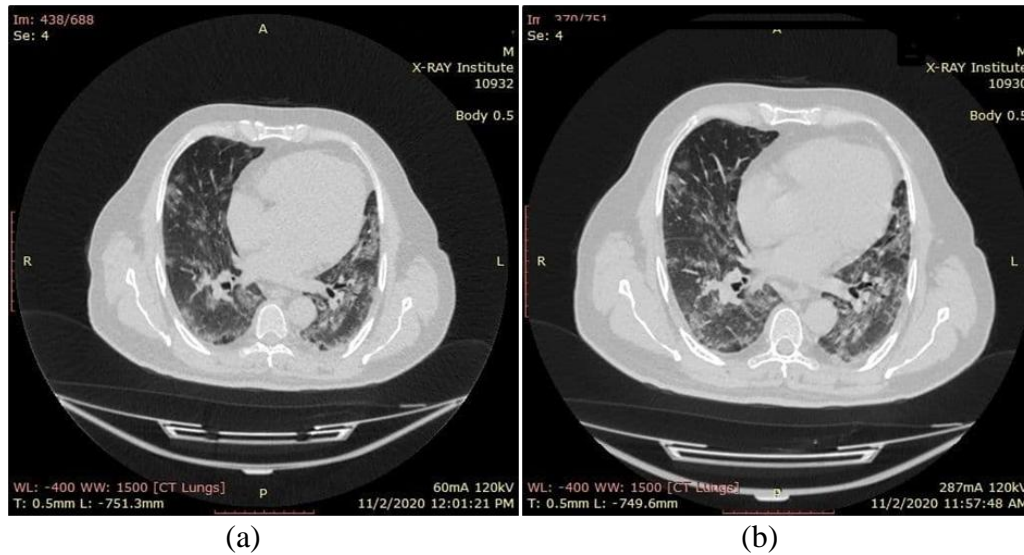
Chest CT scan of a 56-year-old man with COVID -19; (a) Standard-dose image, (b) the low-dose image.
